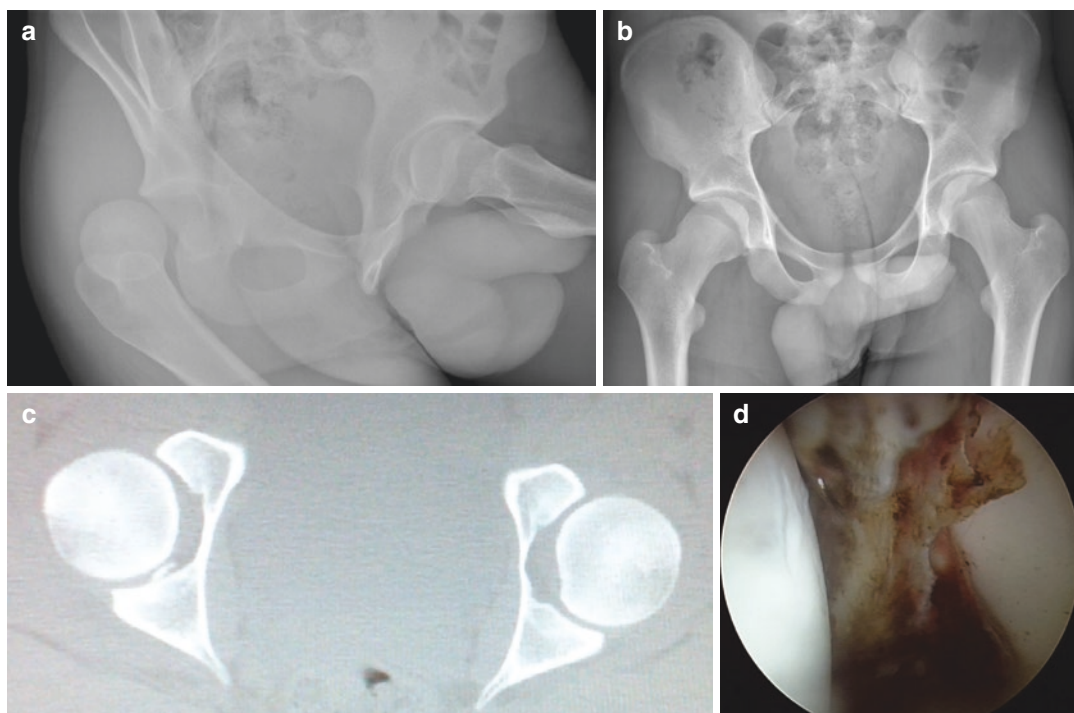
(a) AP-pelvis x-ray showing a posterior hip dislocation. (b) X-ray of the same patient after reduction. (c) CT scan of the same patient showing an intra-articular
